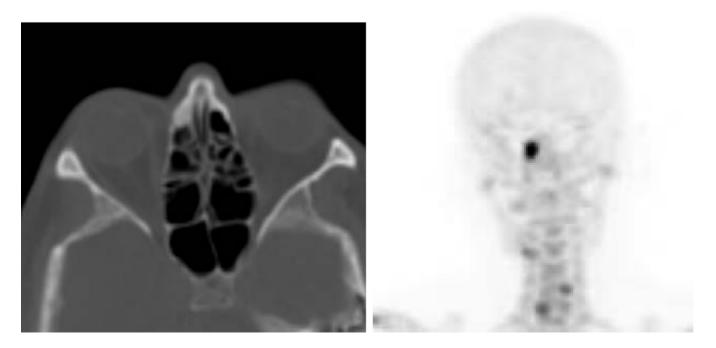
Incidental finding of fibrous dysplasia on NaF-PET/CT. Right nasal bone appears characteristically opaque and expansile.
